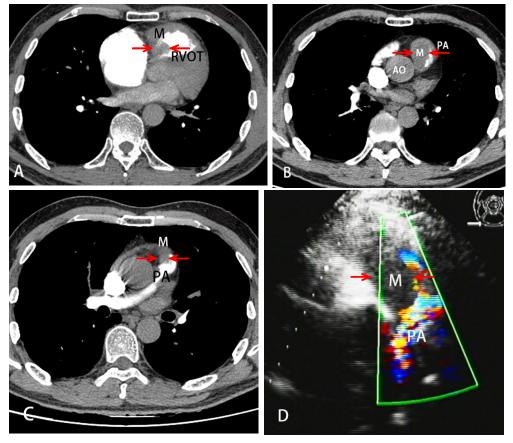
A) Pulmonary computed tomography angiography showing intravascular filling defects of pulmonary trunk occupying right ventricular outflow tract. B) The mass nearly filling the entire pulmonary cavity. C) The tumor extending distal to the pulmonary artery branch. D) Transthoracic echocardiography showing a filling defect of the pulmonary artery.
